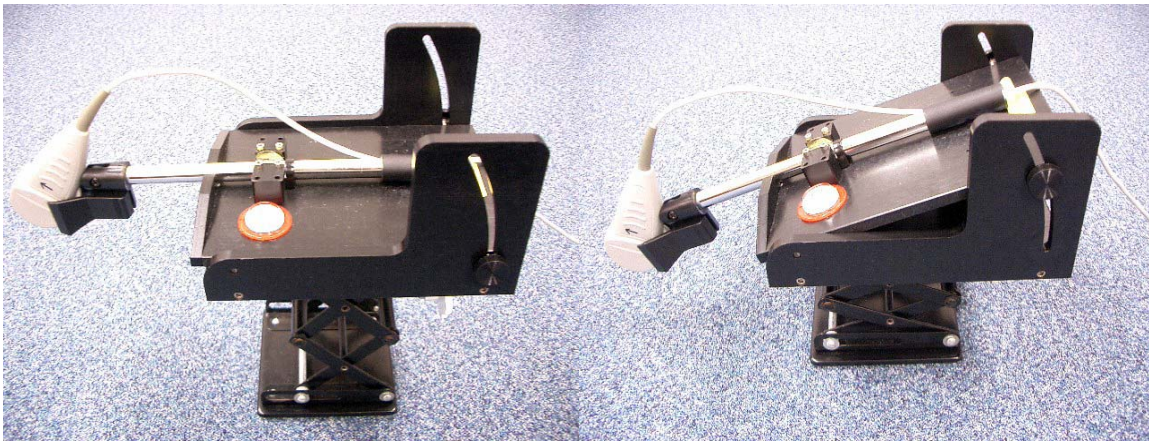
Static location and inclination angle of the ultrasound probe were adjustable. The axial VMO image can be captured with minimal compression on the top of the VMO.
